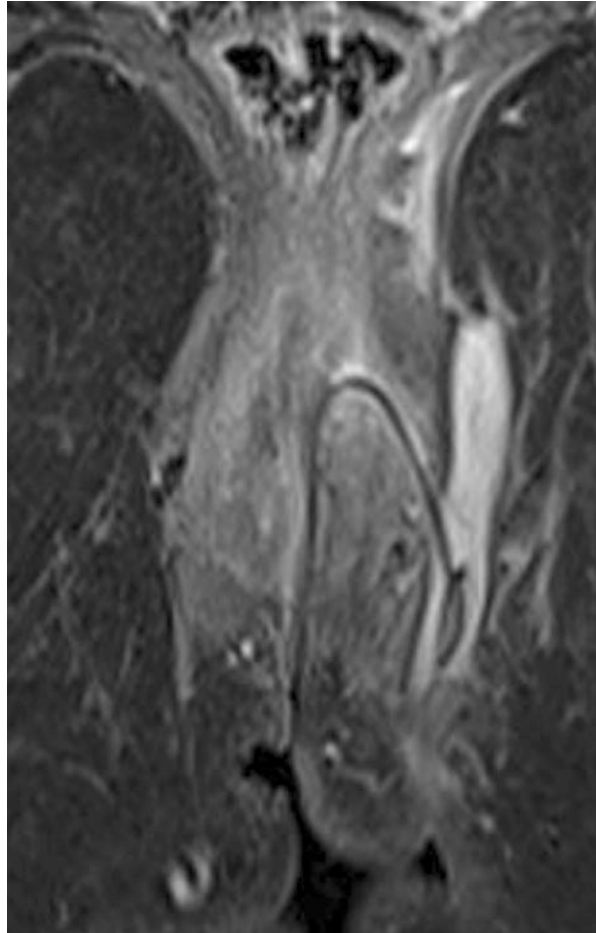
Coronal MRI with active perianal sepsis—high T2 signal fluid within suprasphincteric fistula
